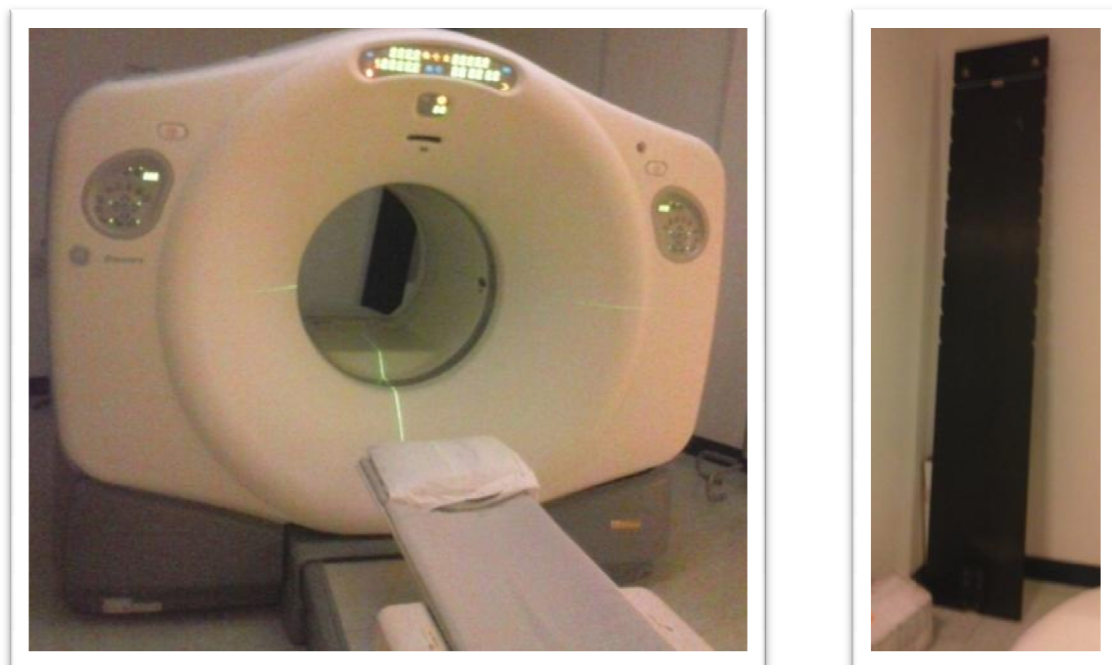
Pictures from the PET/CT room designated for RT planning (on the left) and a more detailed view of the carbon fiber couchtop, stored in the back of the room when is not being used (on the right).
